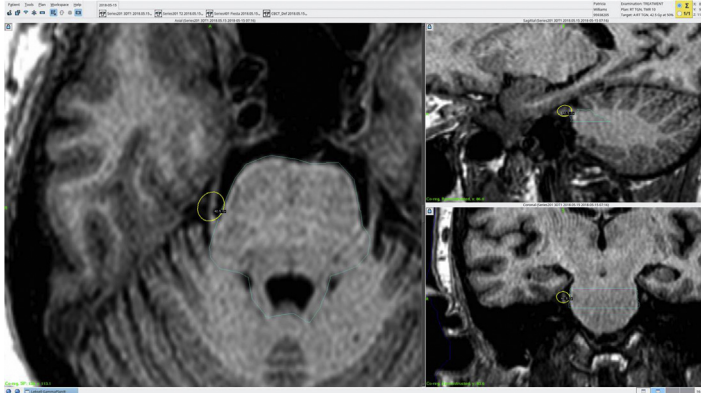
High-resolution MRI with the target trigeminal nerve clearly identified for Gamma Knife radiosurgery treatment planning.
